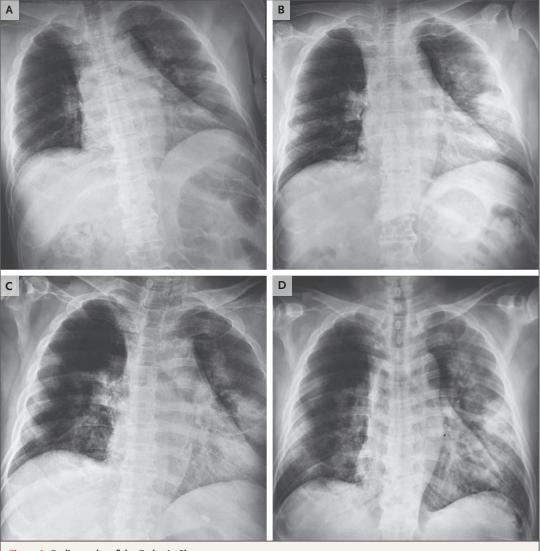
Radiographs of the Father's Chest. Shown are chest radiographs obtained at admission (Panel A) and on day 3 (Panel B), day 5 (Panel C), and day 6 (Panel D) after admission.
